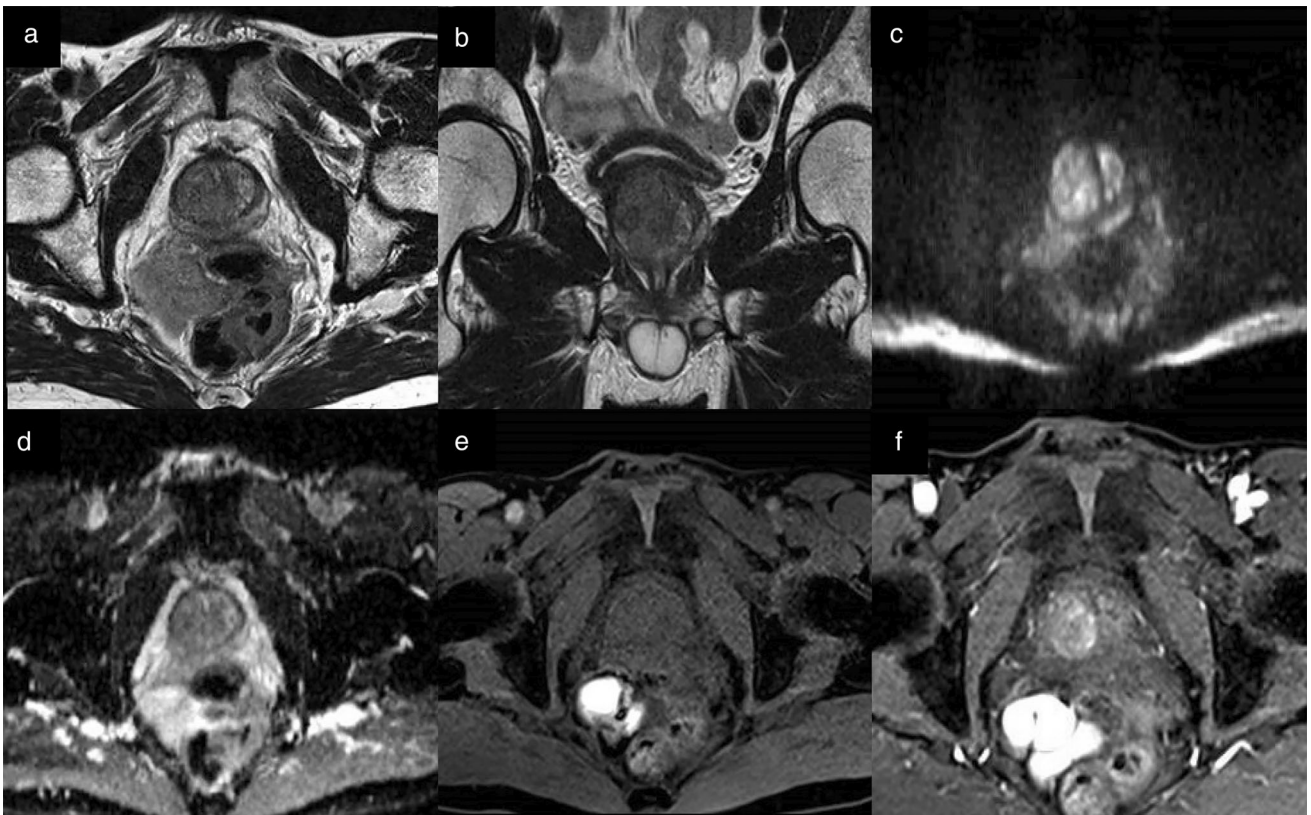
Axial (a) and coronal (b) T2-weighted imaging, high b value (1400 seconds/mm²) (c), ADC map (d) and pre-contrast (e) and DCE acquisitions (f) of a study that was given a PI-QUAL score of 3. At least two MR sequences taken together are of diagnostic quality, as there are motion artifacts on T2-WI and artifacts from rectal distension on DWI.
